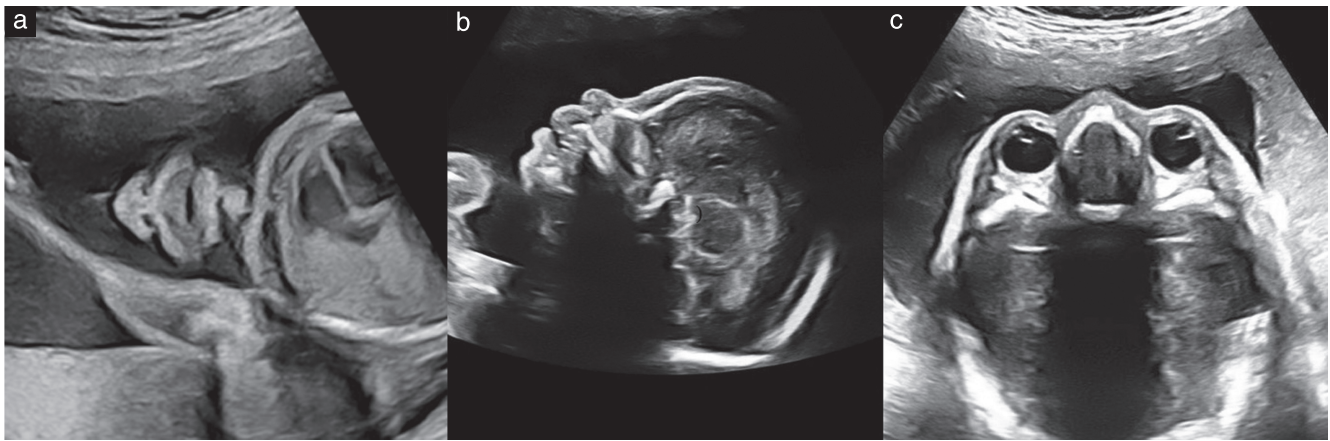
Ultrasound imaging of the fetal face. (a) The mouth, lips and nose are typically evaluated in a coronal view. (b) If technically feasible, a midsagittal facial profile should be obtained, as it provides important diagnostic clues for bilateral cleft lip, frontal bossing, micrognathia and nasal-bone anomalies. (Note that examination of the nasal bone is optional.) (c) Both fetal orbits should appear symmetrical and intact, with eyes separated by approximately the diameter of one orbit.
